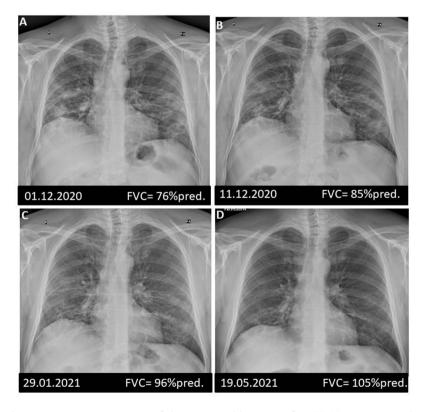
Chest X-ray and spirometric measurements of the 45-year-old patient after COVID-pneumonia during a continued steroid treatment: A - baseline, B - after 10 days, C - after 1,5 month, D - after 5 months. FVC, forced vital volume.
